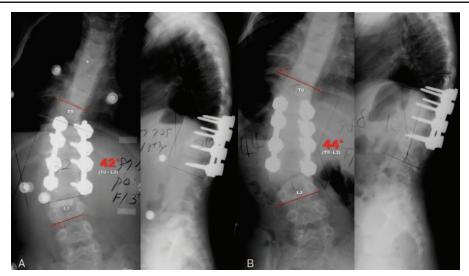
(A) Radiographs taken 3 months after the initial surgery showing that the main curve of scoliosis improved to 42° and segmental angle of kyphosis to 20°. (B) Sixteen-month follow-up radiographs showing that main curve (T9–L3: 44°) and fusion mass (T10–L2: 33°) were well maintained with slight progression of the distal compensatory curve from 14° to 18°.
